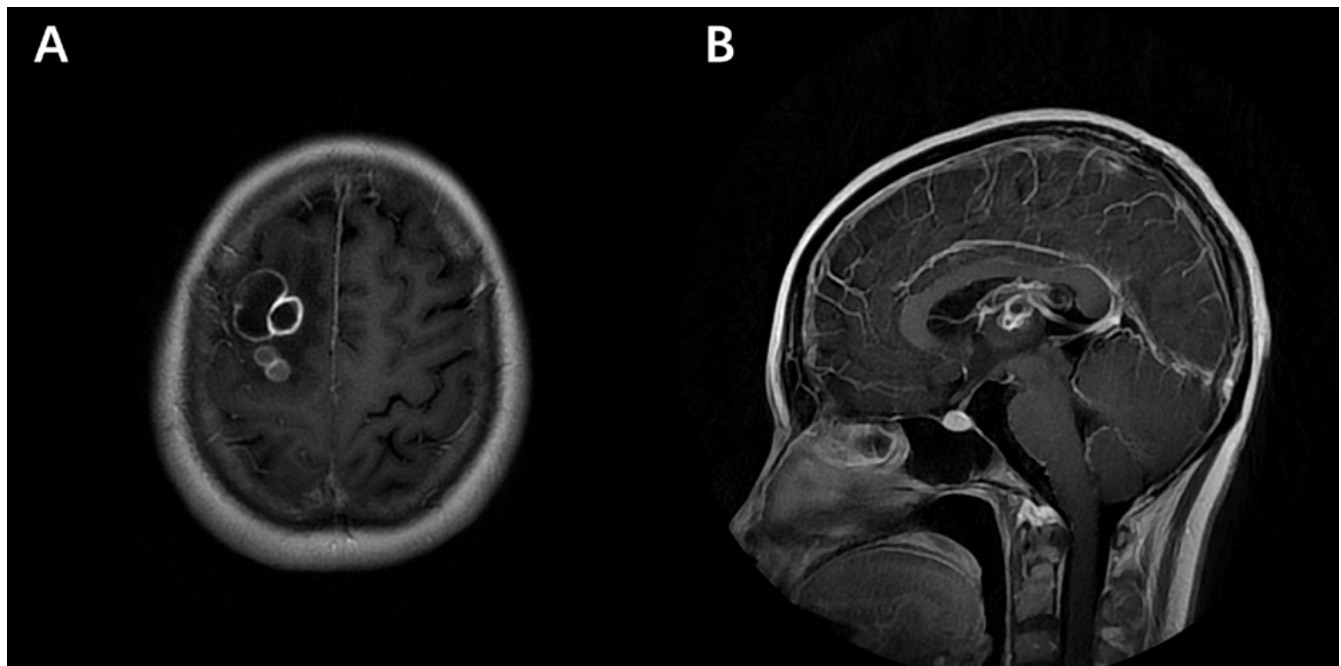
Representative magnetic resonance images (MRI) images of the patients. A. The axial gadolinium-enhanced MRI image of case 8 shows multiple ring-enhancing lesions of varying sizes in the right frontal and parietal lobes; B. Sagittal T1 gadolinium-enhanced MRI image of case 6 shows ring-enhancing lesions in the right basal ganglia, with meningeal enhancement
